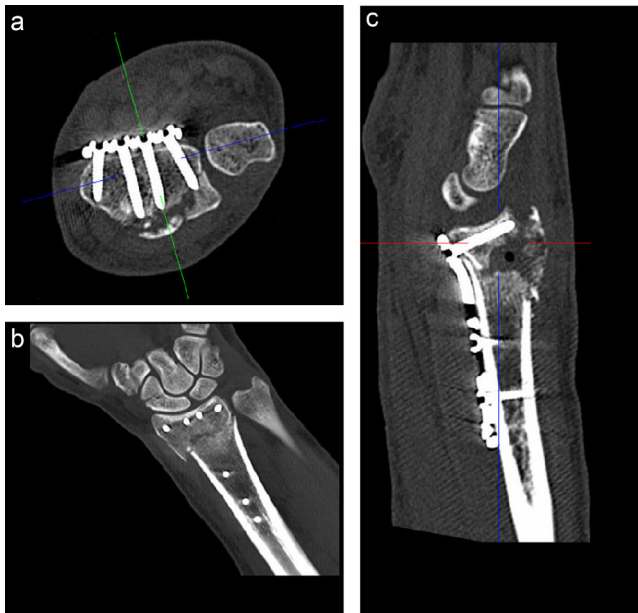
a–c: CT imaging of LCP plate osteosynthesis at the distal radius. CT served as the gold standard of the study. The 3D-angulation allows exact location of every screw-up to the screw-tip without disturbing artefacts.
